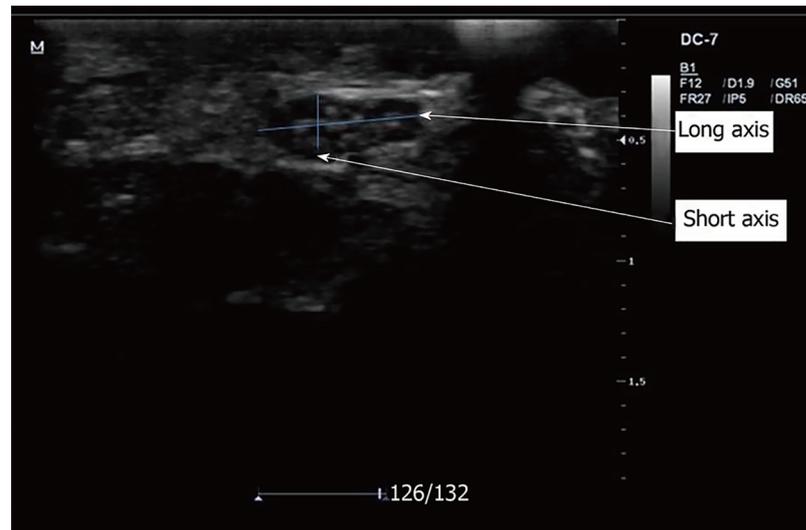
Transverse B-mode sonogram of the median nerve showing its long and short axes.
